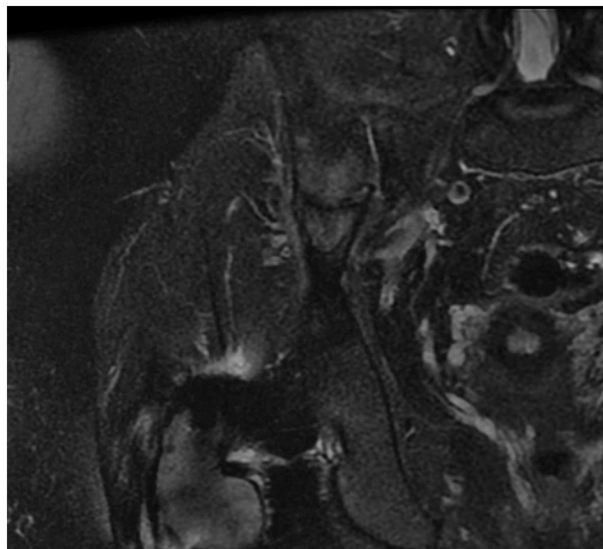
MRI T2 coronal image of the right hip showing insufficiency fracture of the right iliac wing.
